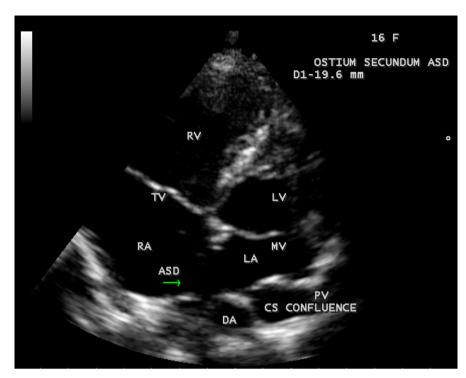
Showing the pulmonary venous confluence and ostium secundum ASD (atrial septal defect) in apical four chamber view (the size of secundum ASD is 19.6 mm).
